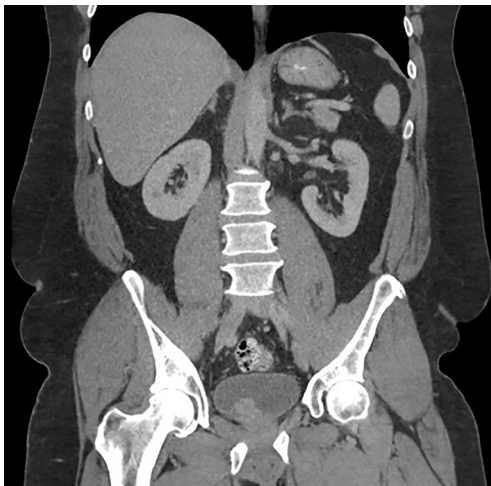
CT abdomen/pelvis, prior to any TURBT, demonstrating an enhancing mass along the right inferior urinary bladder. CT, computed tomography; TURBT, transurethral resection of bladder tumor.
